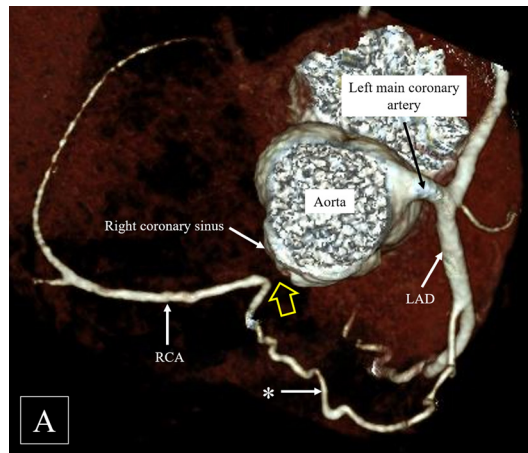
Volume-rendered CT angiography image reveals ostial atresia (yellow arrow) of the right coronary artery (RCA). RCA distal to the atretic segment is reformed by a tortuous vessel (*) arising from the left anterior descending (LAD) artery.
